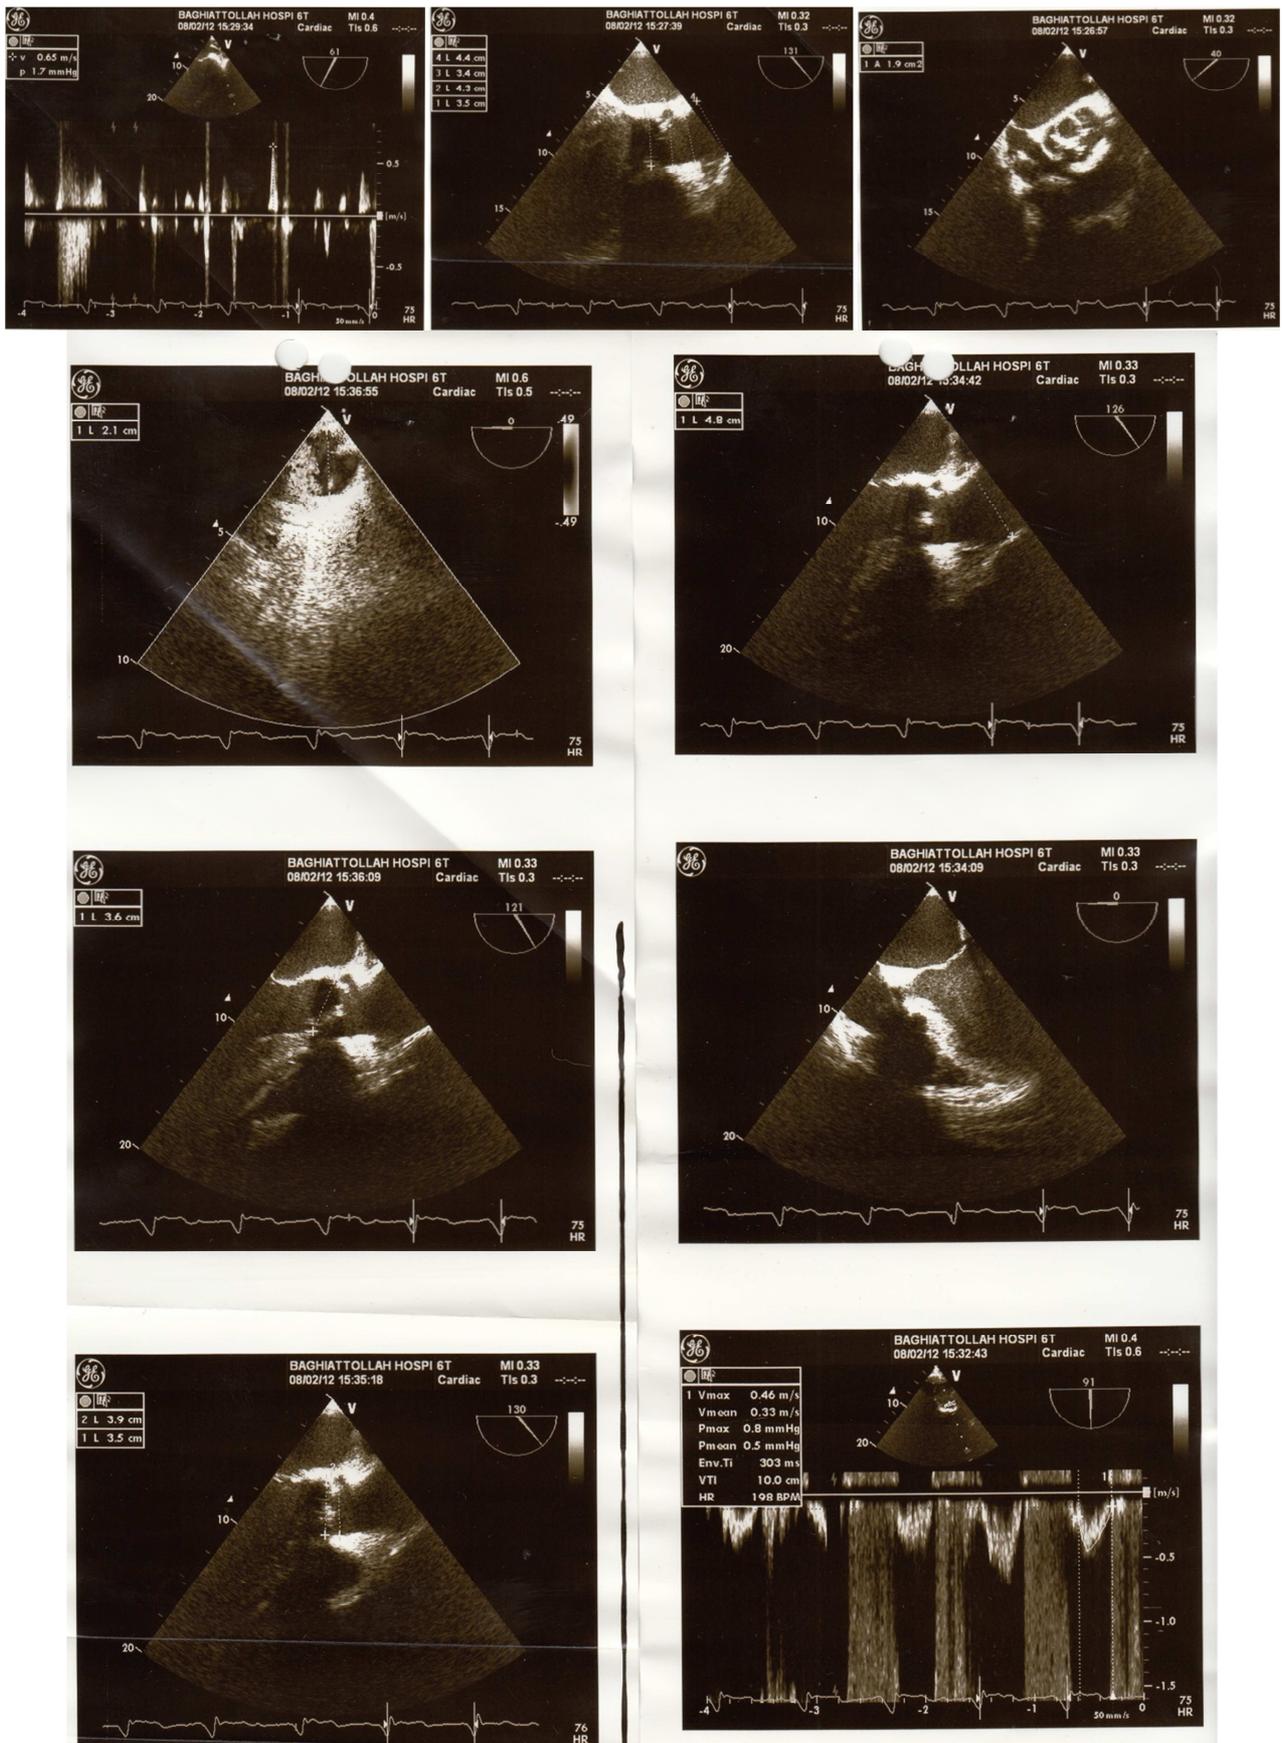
Echocardiography findings at admission
